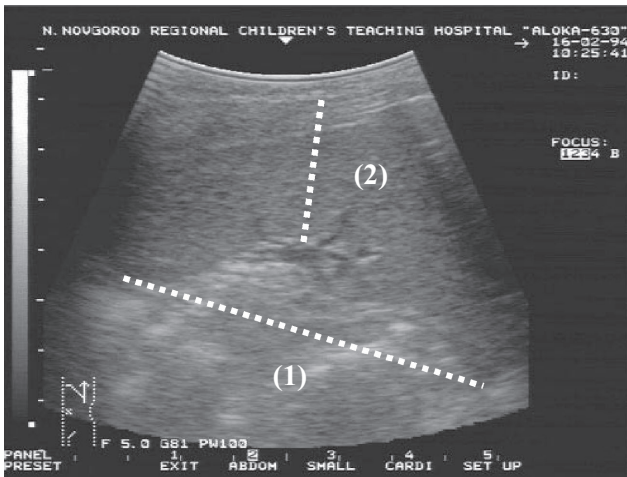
The picture of splenic measurement by ultrasound
